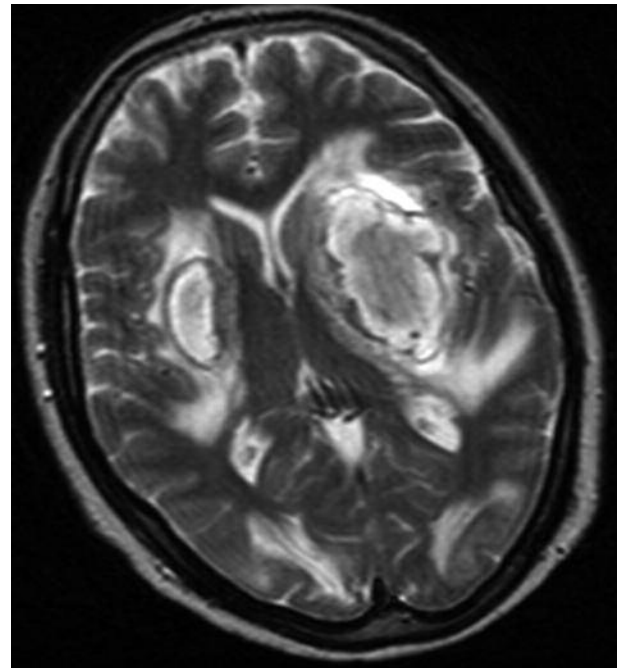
T2-weighted Brain MRI, 7 days after the attack, shows subacute hemorrhagic necrosis in bilateral Basal ganglia, and abnormal high signal intensity in occipital areas.
